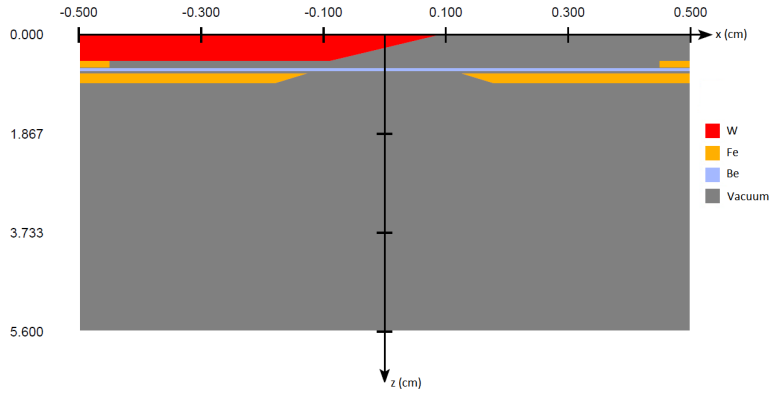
Design of the 130 kV Hamamatsu directional X-ray tube as specified in BEAMnrc
